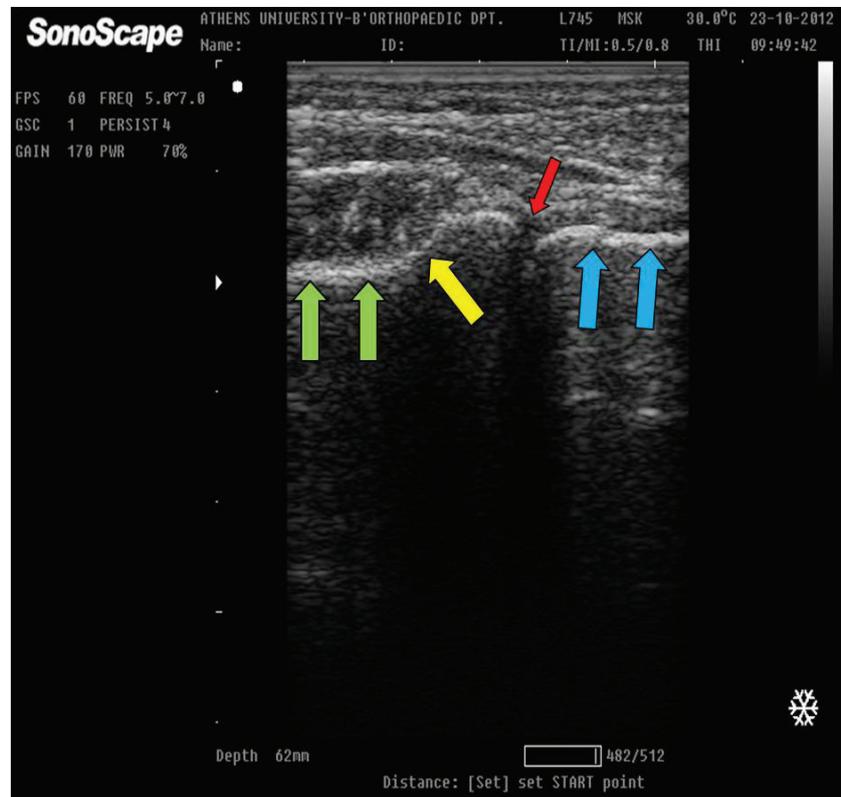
Longitudinal sonographic image of the radiocapitellar joint (red arrow), the proximal radius (green arrows) and the distal humerus (light blue arrows). Cortical discontinuity of the radial neck (yellow arrow) as a direct sign of a radiographically occult radial head fracture.
